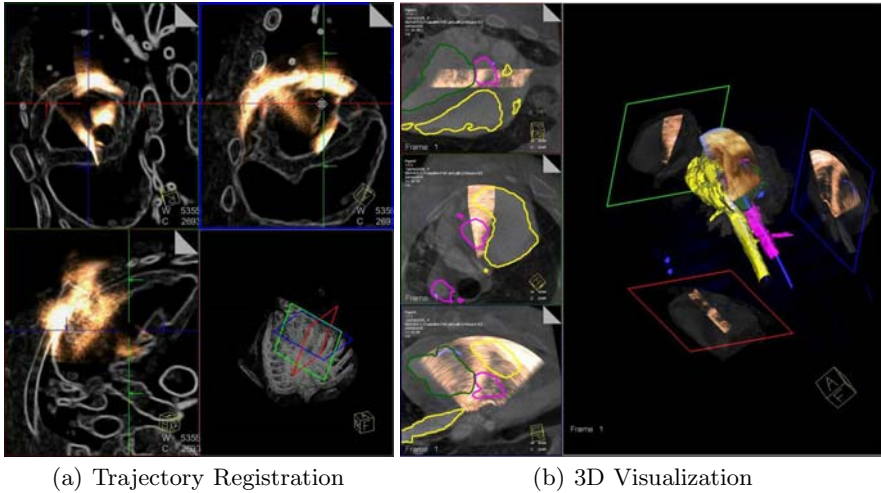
Cross-sections of CT reflection overlaid with single end-diastole ICE volume
